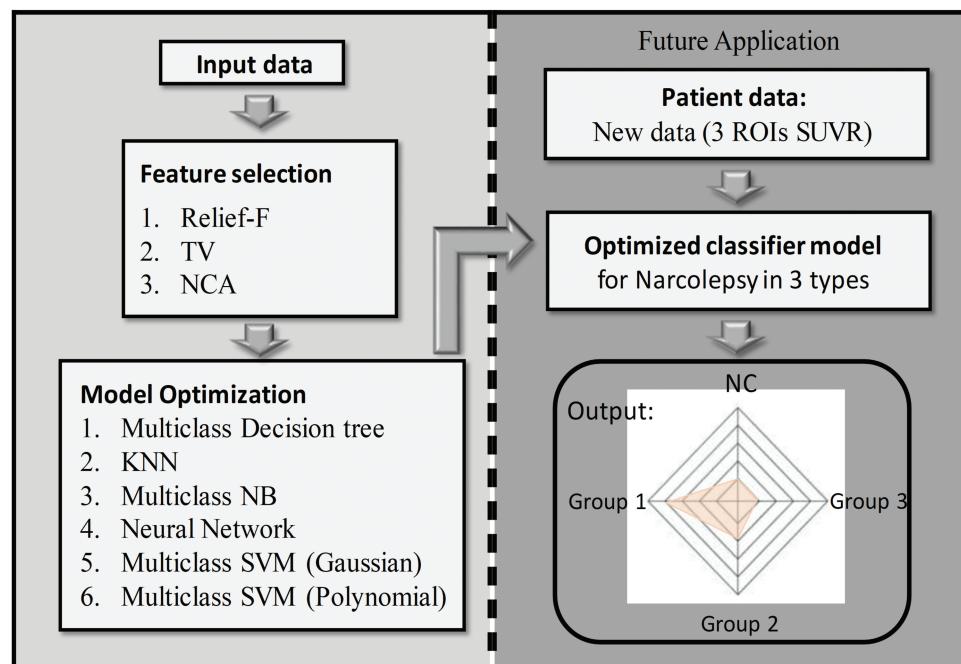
Processing contains four steps: the regional SUVR data is applied as input data in step 1. Three methods of feature selection to rank the importance of features are applied in step 2, while step 3 indicates the automatic optimization of hyperparameters for six classification models. In step 4, an optimized classifier model is chosen as the best model, and a new dataset is applied to the optimized model to predict the subtype of the disease. KNN, K-nearest neighbor; NB, naive bayes; NCA, neighborhood component analysis; ROIs SUVR, region-of-interest's standard uptake value ratio; SVM, support vector machines; TV, term variance.
